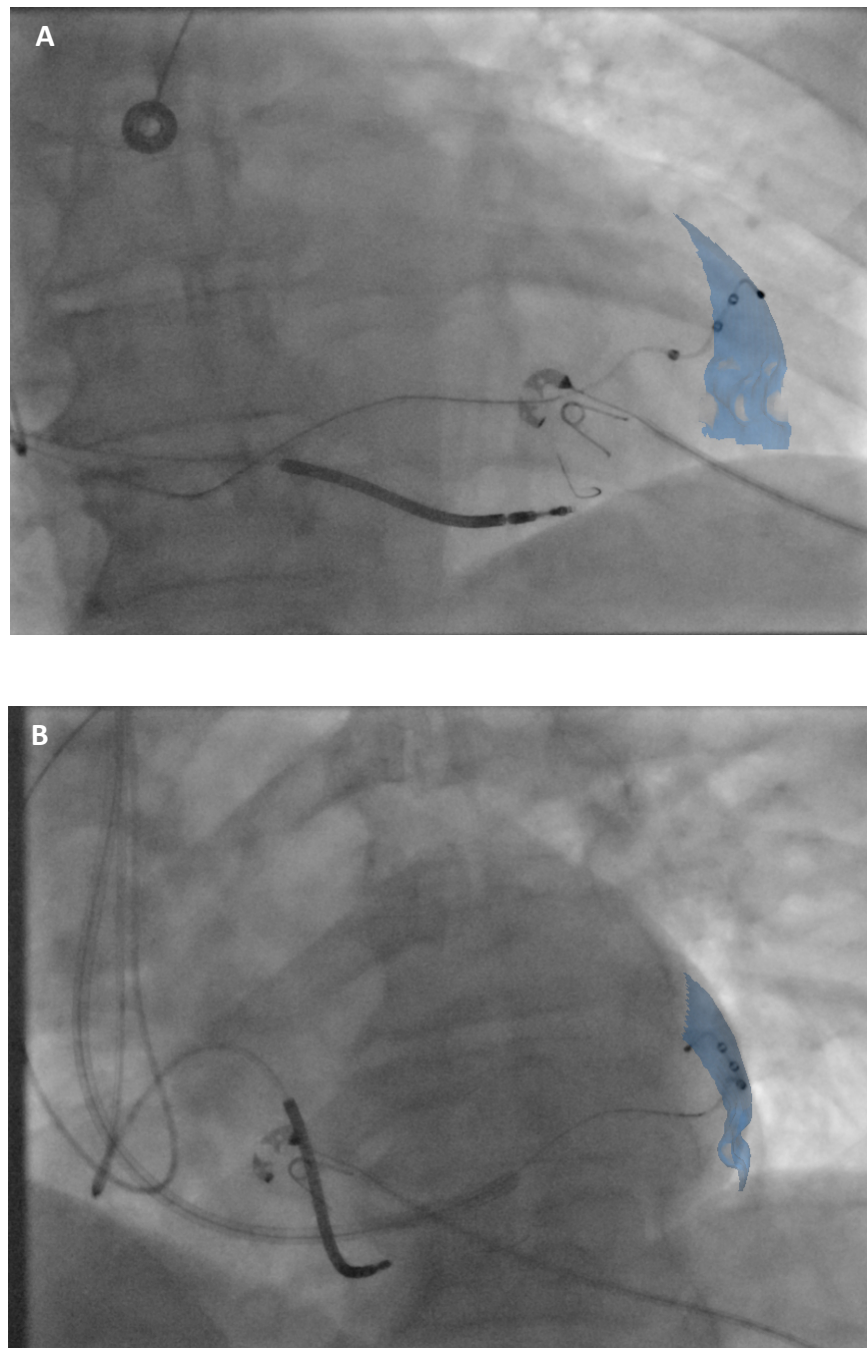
Real-time Cardiac CT image overlay guidance
